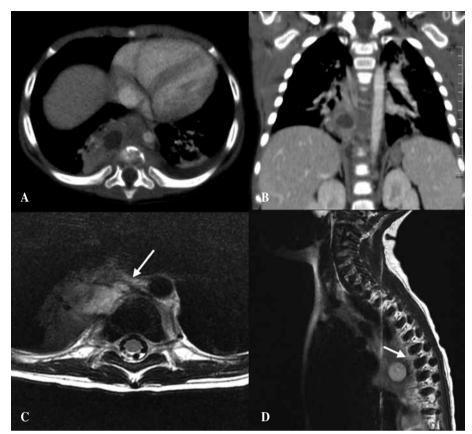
Pulmonary aspergilloma with spondylodiscitis. A) Pulmonary CT-scan axial cut: cavitated lesion in the right pulmonary base, with presence of fungal ball inside. Spondylodiscitis visible. B) Pulmonary CT-scan coronal cut. C) T1-weighted MRI axial cut demonstrating PA spondylodiscitis. D) T1-weighted MRI sagittal cut demonstrating T6-T8 PA spondylodiscitis.
